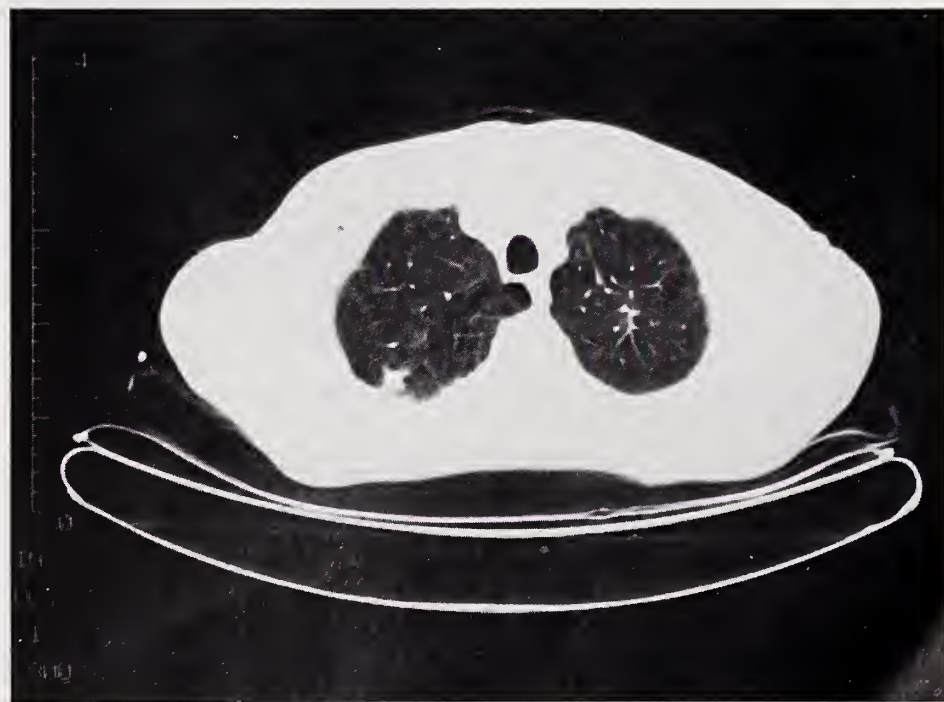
CT demonstrating a 1.5 cm irregular mass in the posterior segment of the right upper lobe.
